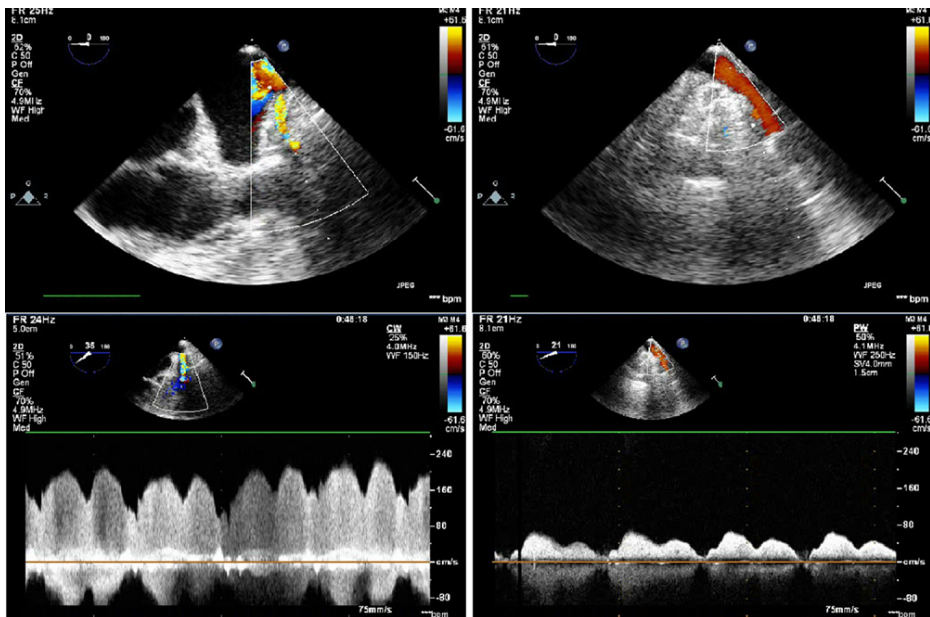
Transesophageal echocardiographic images of the left superior pulmonary vein (LSPV) (right) and left inferior pulmonary vein (LIPV) (left). Turbulent flow with high peak flow velocities (2 m/s, normal 0.2 cm/s to 1 m/s) is present in the LSPV compared to laminar flow with normal peak flow velocities in the LIPV.
